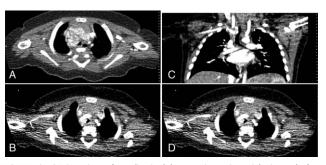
CT imaging of mediastinal hemangioma in axial views; before propranolol treatment (A), after 3 months of propranolol treatment (B). The lesion is identified by the arrow. CT imaging showing mediastinal hemangioma in coronal views; (C) before propranolol treatment, (D) after 3 months of propranolol treatment. The lesion is identified by the arrow.
